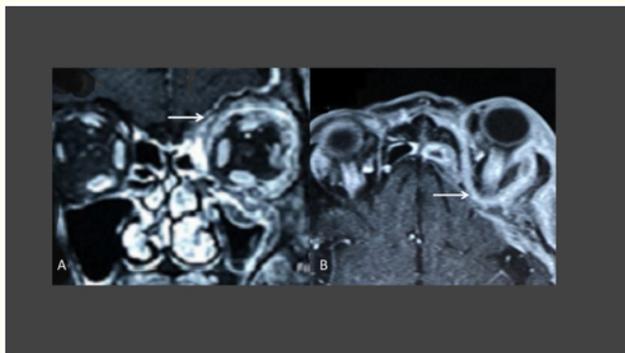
In T1 weighted fat suppression MRI after contrast injection, both coronal (A) and axial (B) views, demonstrating encircle significant thickening (arrow) around orbital cavity with soft tissue enhancement. There is not any invasion into the orbital cavity.
